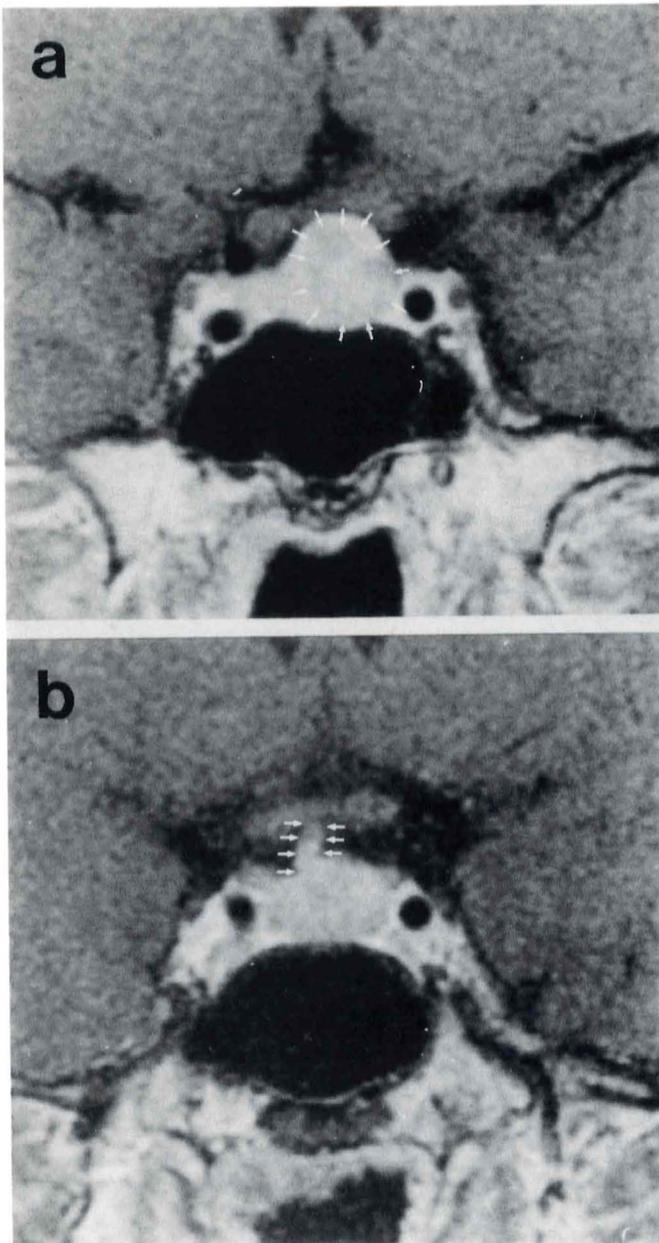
Preoperative control T1-weighted spin-echo MRI. a, Arrows show a small round mass (1.0 × 0.9 × 0.8 cm) which is restricted in the sellar space; b, arrows show a deviation of the stalk.
